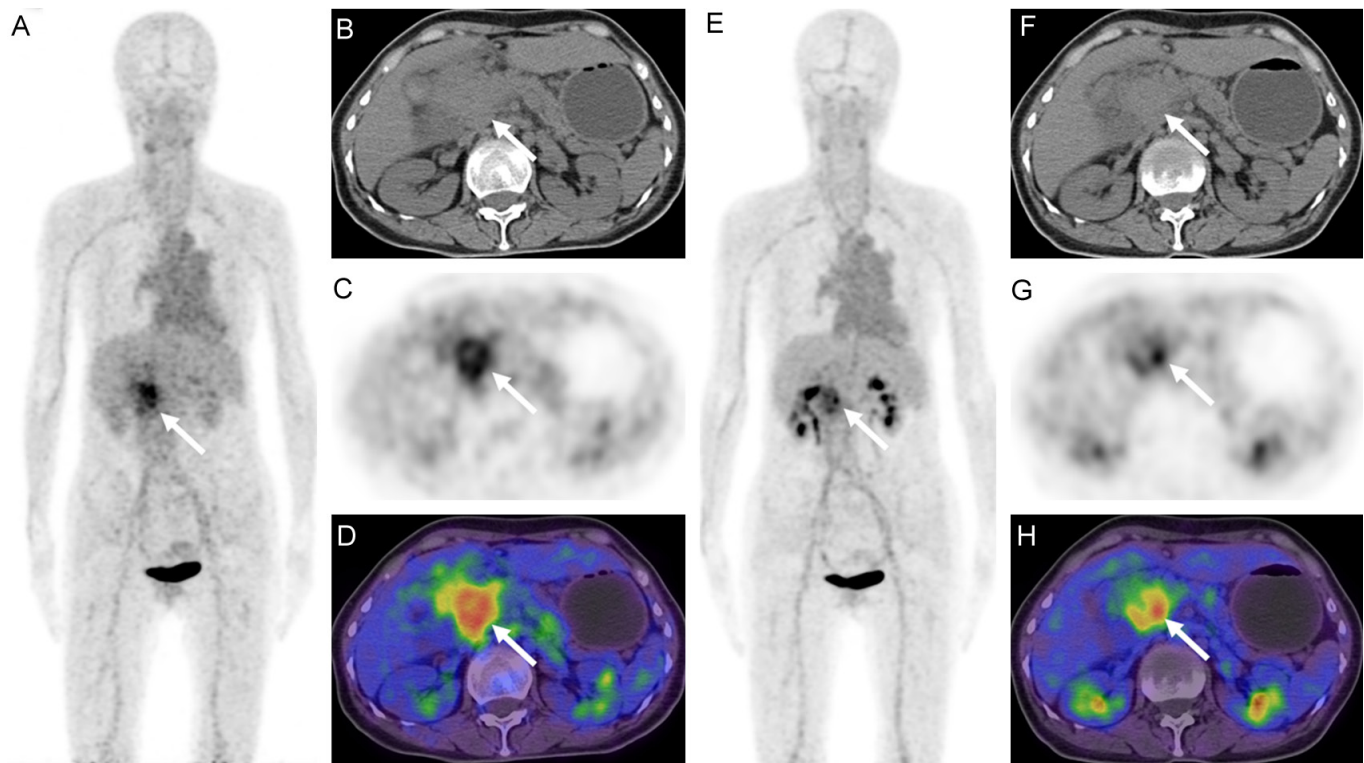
A 65-year-old woman with pancreatic head cancer. 15 min MIP imaging (A) shows a concentrated radioactive image in the upper abdomen. Axial CT (B) reveals an isodense mass in the pancreatic head with indistinct boundaries. Corresponding axial PET (C) and fusion (D) images at the same level indicate increased radioactive uptake in the mass, with SUV_{max} of 12.4, SUV_{mean} of 6.5, SUV_{peak} of 8.8, SUV_{liver} of 2.3, and UTV of 20.1. The 60min MIP (E), CT (F), PET (G), and fusion (H) images are similar to those at 15 min, with SUV_{max} of 11.3, SUV_{mean} of 6.3, SUV_{peak} of 8.5, SUV_{liver} of 2.0, and UTV of 17.5.
